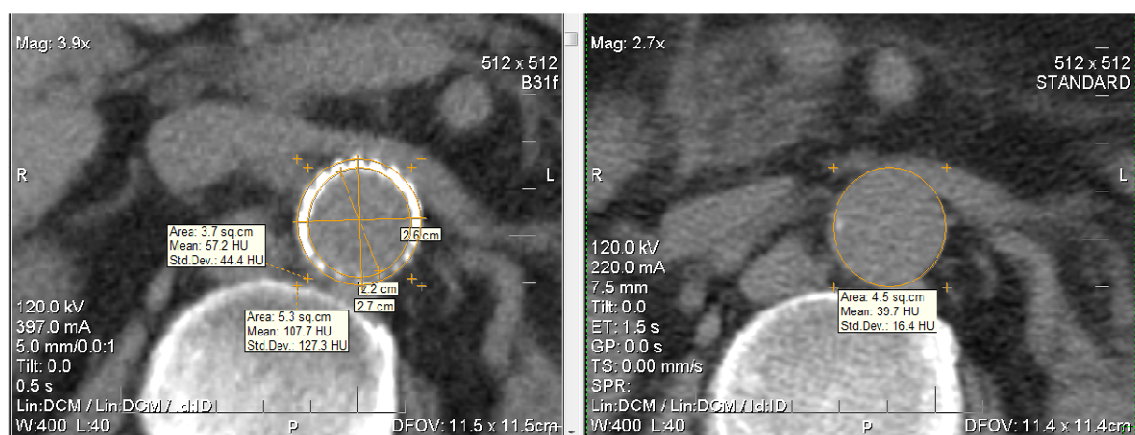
Figure showing post-op and pre-op CT scan slices at approximately the same proximal neck level.
